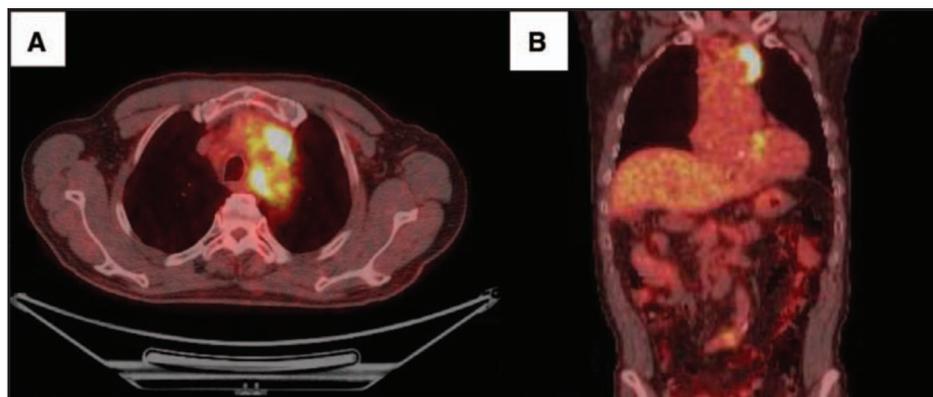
FDG-PET at first visit. *A*, Axial view, *B*, coronal view. There was significant uptake (maximum standardized uptake value = 10.8) at the tumor site. FDG-PET, fluorodeoxyglucose positron emission tomography.
